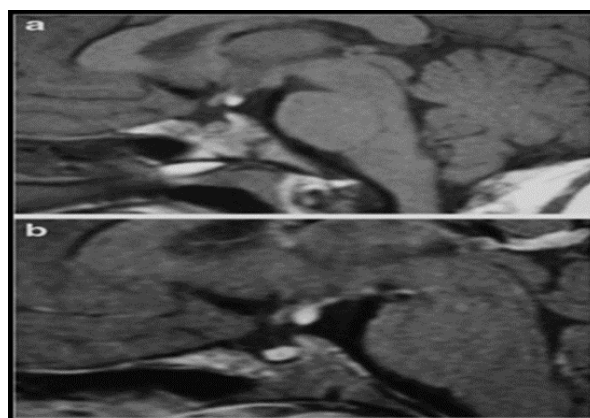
Ectopic posterior pituitary gland. Pre-contrast (a) & post-contrast (b) MR images (11).
